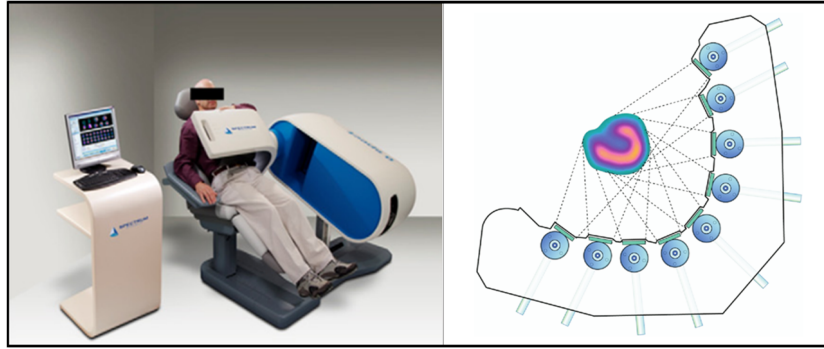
D-SPECT system. On the left, the figure shows the positioning of the patient and the camera. On the right, details of the configuration of the 9 detectors and the region of the heart are shown. Image adapted^{15,19}.
